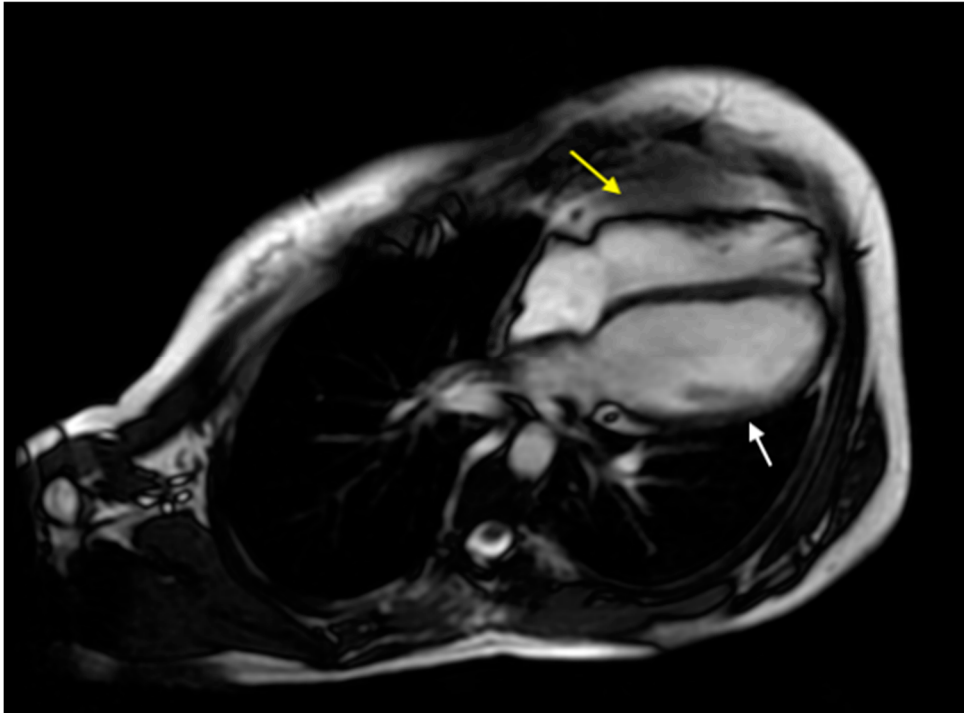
Cardiac MRI in the four-chamber cine view, demonstrating the pericardium as a thin linear structure anterior to the right ventricle, interposed between epicardial and mediastinal fat tissue (yellow arrow). The pericardium is not visualized posterior to the left-sided cardiac chambers (white arrow).
